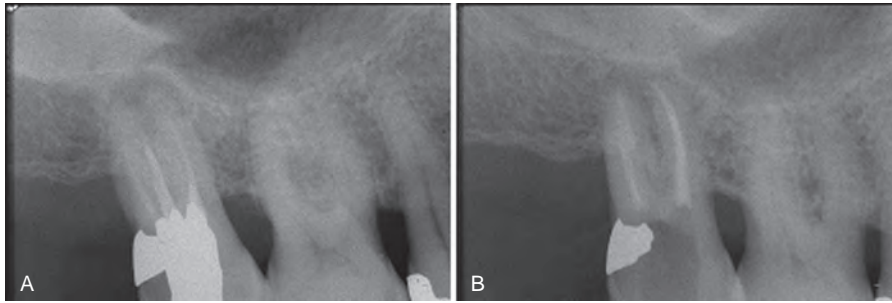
(A) Second upper molar x-ray showed a chronic apical periodontitis on the mesiobuccal root. (B) Bone reconstitution appeared complete in the last second upper molar x-ray.
